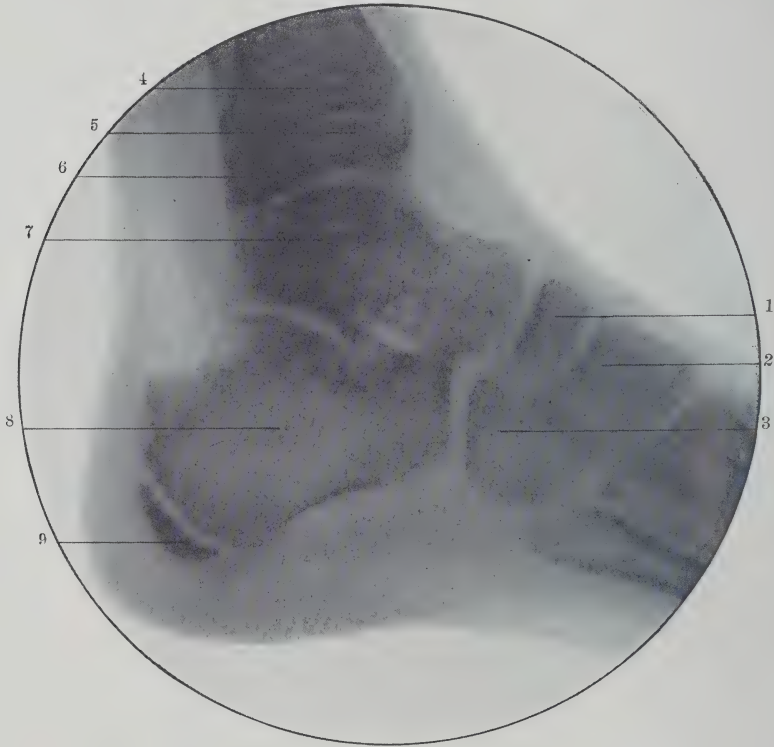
Radiograph Showing Lateral View of Ankle at Twelve Years. 1, Scaphoid; 2, internal cuneiform; 3, cuboid; 4, tibia; 5, lower epiphysis of tibia; 6, fibula; 7, astragalus; 8, os calcis; 9, epiphysis of os calcis. (Original.)
